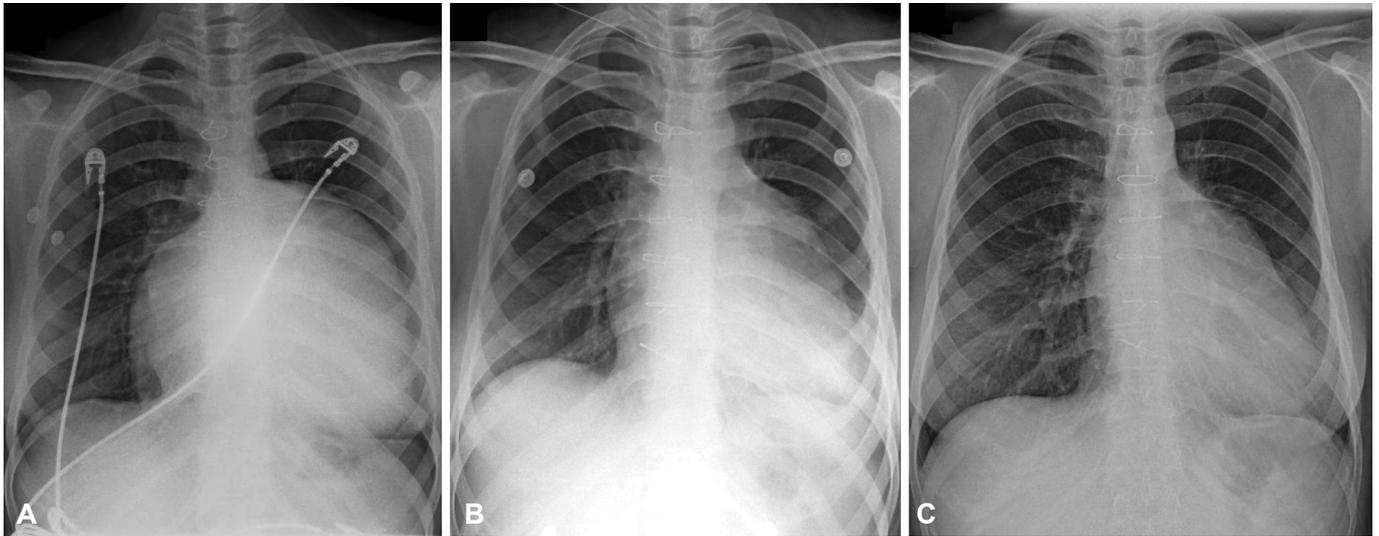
Cardiomegaly has been improved on serial chest X-ray. (A) Before operation (B) Post-operative day 19 (C) 3 years after operation.
